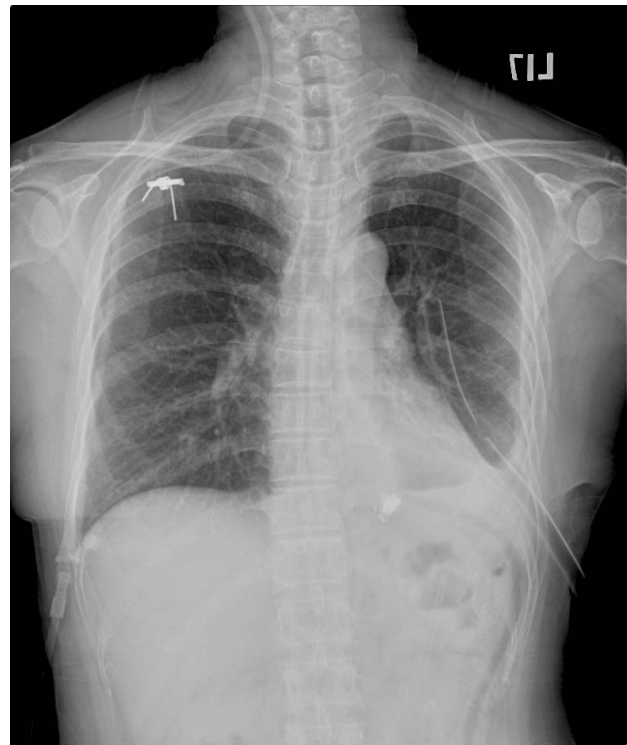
At 2 weeks after the endoscopic treatment, the follow-up chest X-ray showed intact n-butyl-2-cyanoacrylate in place and clear lung field.
